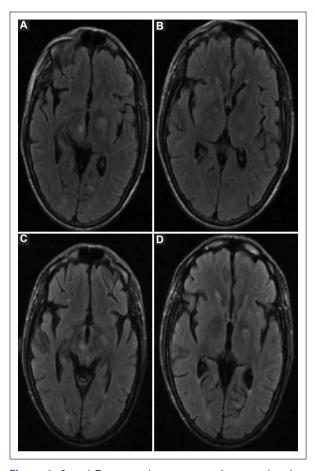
A and B: magnetic resonance images showing oval lesions localized bilaterally in basal ganglia and in left thalamus in fluid-attenuated inversion recovery T2 sequence. C and D: show the same patient 2 weeks after initiating anti-tuberculous regimen including clarithromycin.
